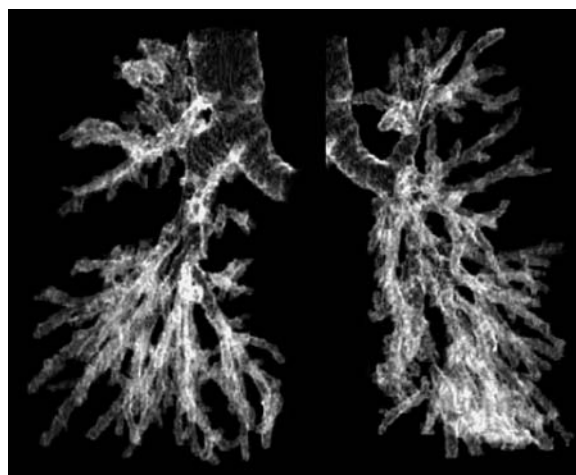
A CT bronchogram after MDCT in a patient with chronic obstructive pulmonary disease (COPD) and diffuse cylindrical bronchiectasis. *Left:* Right bronchogram in a right posterior oblique view. *Right:* Left bronchogram in a left posterior oblique view
